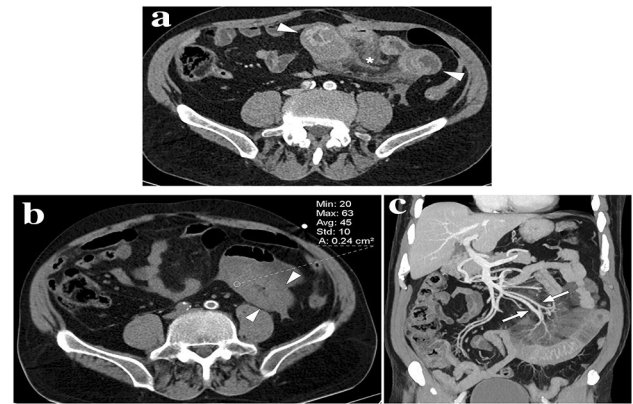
A 68-year-old male patient presented with abdominal pain in the left lower quadrant. The patient was on chronic coumadin use due to prior mitral valve replacement surgery. a Axial plane postcontrast abdominal CT showed diffuse wall thickening in a long segment of distal ileal loops with accompanying mesenteric fat stranding (asterisk) and minimal pelvic free fluid of high density suggesting hemorrhagic nature (not shown). b Axial plane non-enhanced abdominal CT image revealed that the thickened intestinal wall segments have a density of 45 HU, suggesting hemorrhage. It would not be possible to distinguish between bowel wall enhancement versus hemorrhage with only venous phase CT images. c Coronal plane reformatted maximum intensity projection image confirmed the patency of mesenteric arterial/venous structures (arrows) related to the involved bowel segment. Clinical presentation and radiological findings were found to be consistent with spontaneous intestinal intramural hematoma. The INR was found to be significantly elevated after the CT study. The patient responded well to supportive treatment
